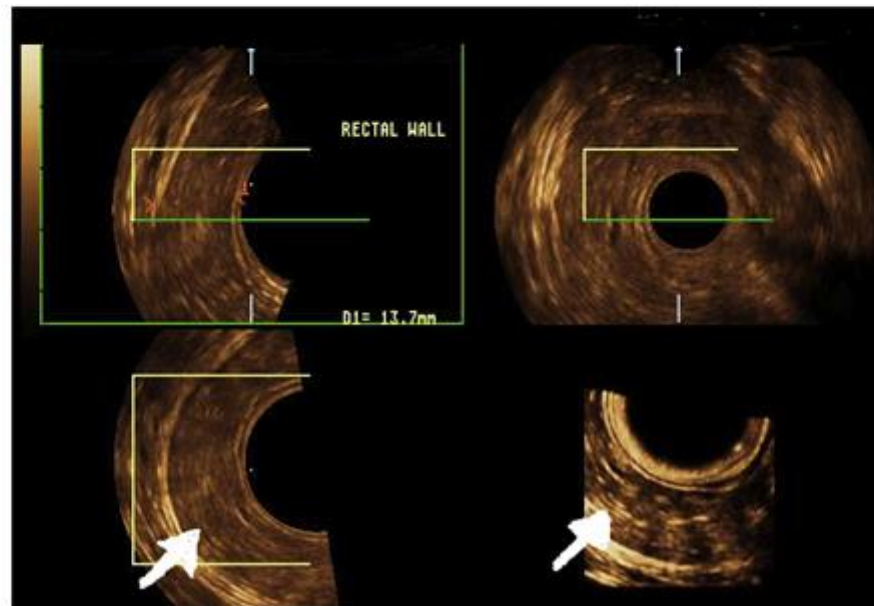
Three-dimensional endoanal ultrasound with multiplanar image analysis and volume rendering of circumferential infiltrative rectal neoplasm (arrows).
